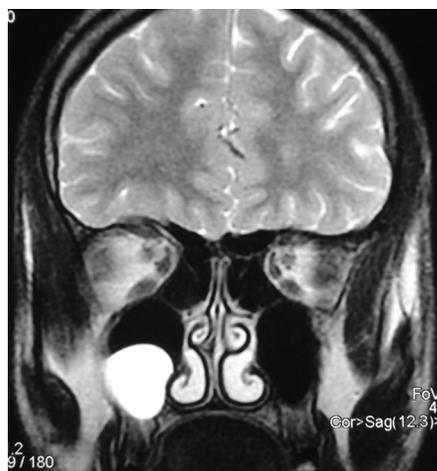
Coronal T2-weighted MR image shows a convex hyperintense lesion in right maxillary antrum suggestive of retention cyst/ polyp
